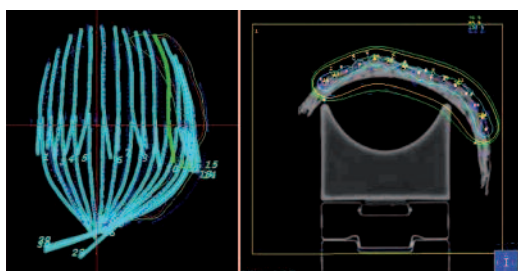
View of reconstructed catheters and calculated dose distribution for the CT based planning
